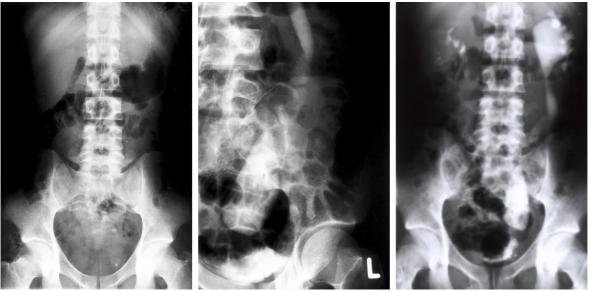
Control abdominal radiograph.
